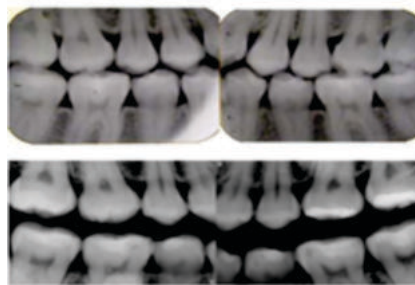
Horizontal bitewing radiograph (Carranza 2012)
